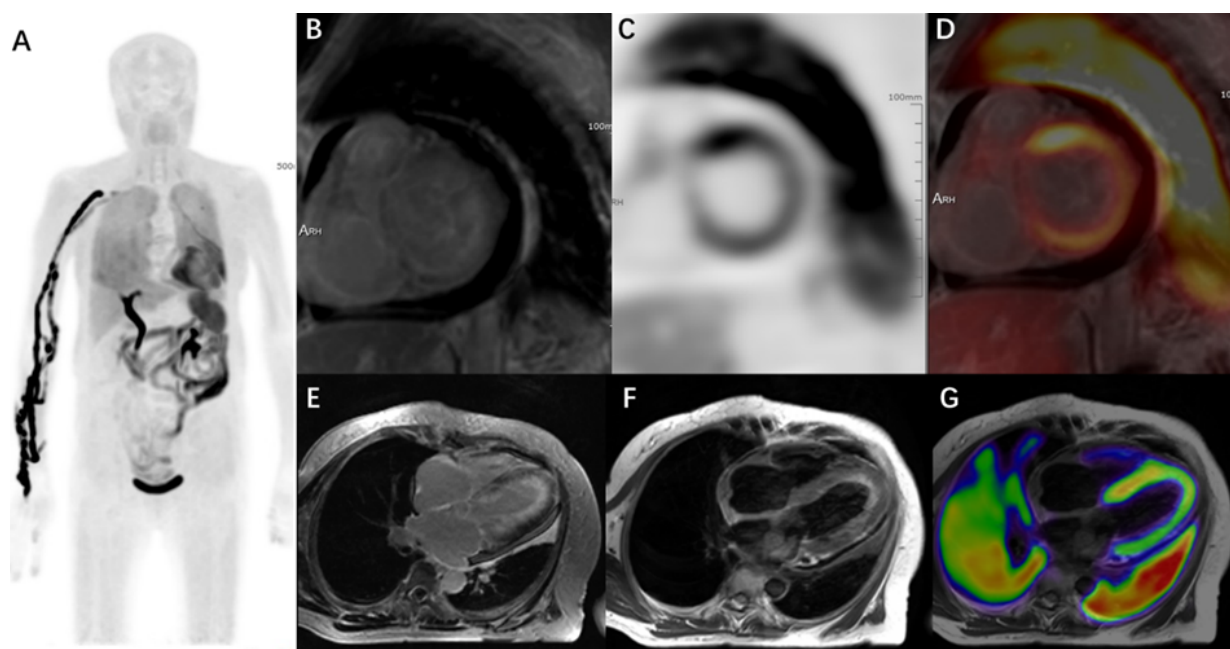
PET/MR images of a patient with cardiac amyloidosis.
